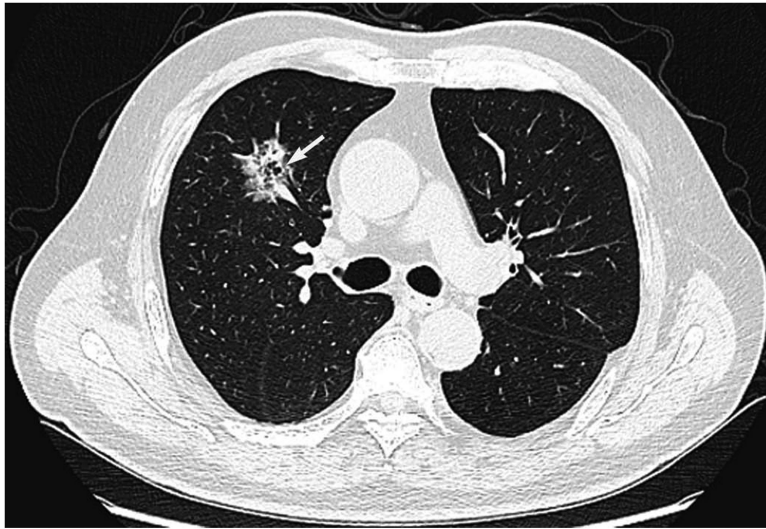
CT image of a 70-year-old man with a lepidic adenocarcinoma harboring *EGFR* mutation shows a subsolid tumor with bubble-like lucency (arrow).
